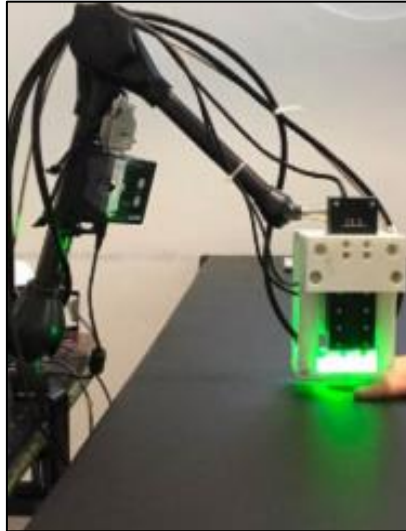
RSOM system. The RSOM system is designed for precise skin measurements. It comprises two fiber bundles for illumination, accompanied by a high-frequency ultrasound transducer that performs a raster scan across the skin's surface.
